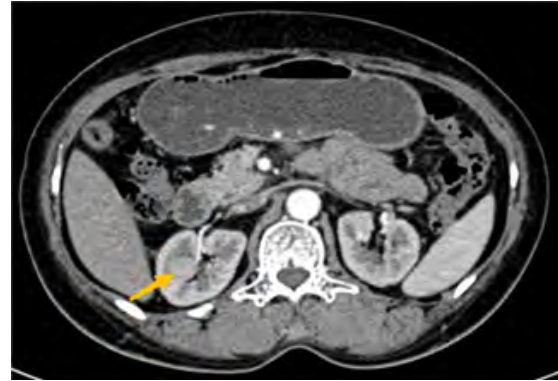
CT scan showed the presence of an endogenous space occupying lesions in the right kidney of case 1, with a size of 3.0 cm × 2.3 cm × 2.2 cm. The yellow arrow points to the renal tumor.
